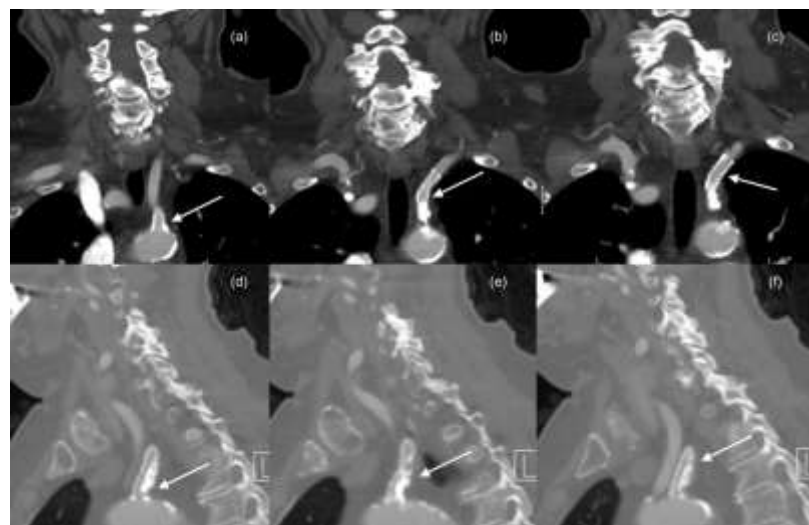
Sequential Coronal (a, b, c) and sagittal (c, d, e) reformatted images of CTA in a 79-year-old female at one month follow-up showing patent left subclavian artery stent (White arrow) with eccentric atherosclerotic plaque pushed towards the posterior wall by the stent.
